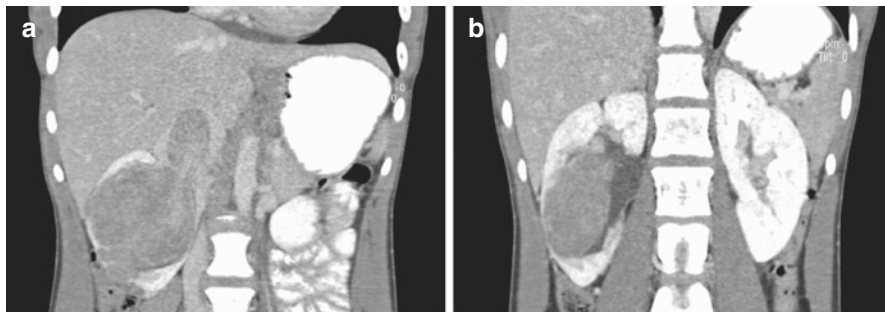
Renal cell carcinoma in a 13-year-old female. (a) Sagittal CT image shows a mass with heterogeneous appearance and tumor thrombus in the inferior vena cava. (b) The tumor can be seen invading the renal sinus
